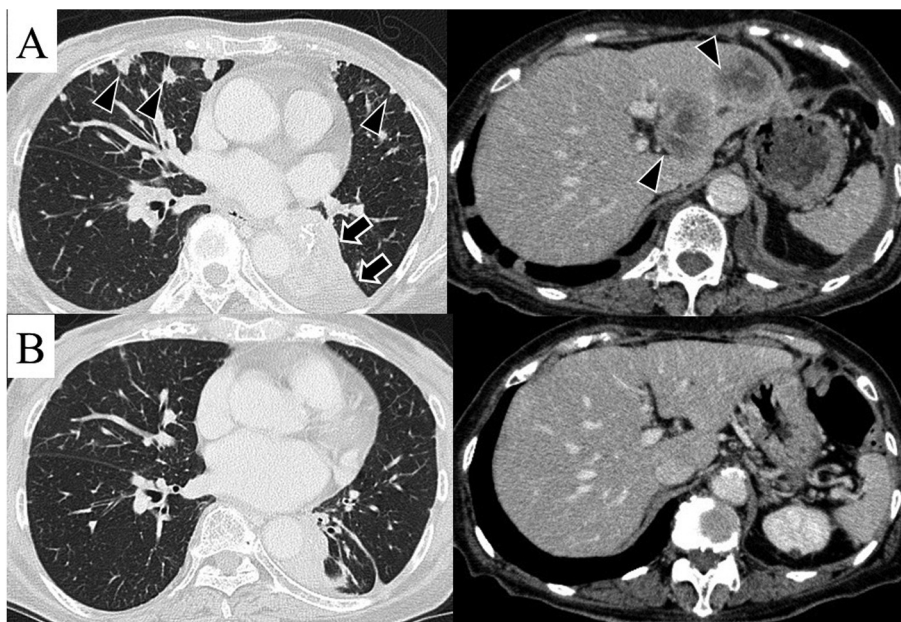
Chest computed tomography of patient 3 showed the primary lesion and atelectasis in left lower lobe of the lung, multiple nodes in both lungs and liver metastases (A). Chest computed tomography scan taken 4 months after the initiation of alectinib showed shrinkage of the primary lesion and disappearance of lung and liver metastases (B).
